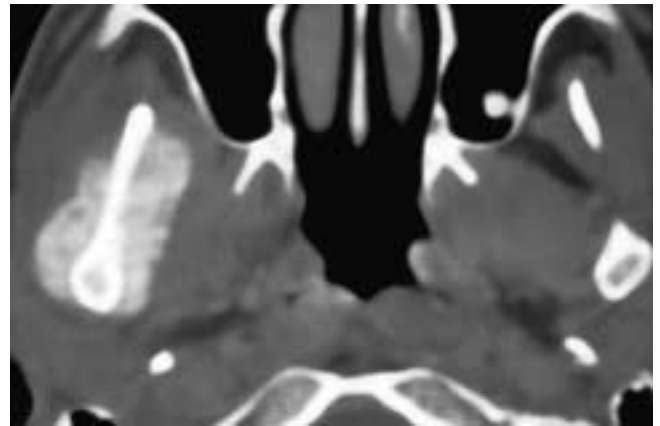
Axial CT scan shows thickening and sclerosis of the right mandibular ramus, with an exuberant periosteal bone reaction along both the buccal and lingual cortices. There was a minimal adjacent soft-tissue mass effect in this patient with an osteosarcoma of the mandible.
